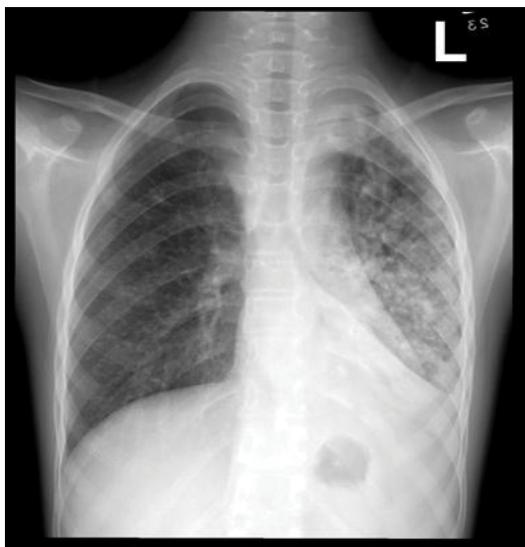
Chest x-ray showing volume loss, and lobar collapse.
